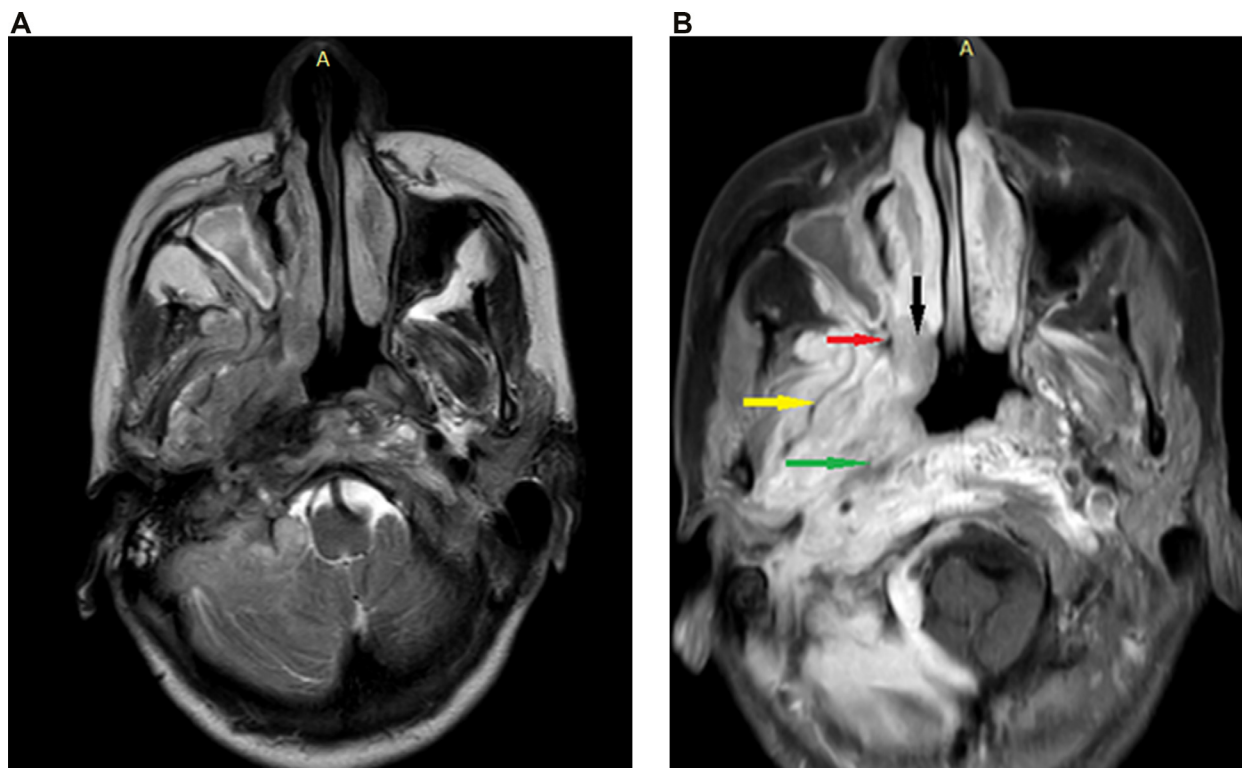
Orbitocerebral MRI, Axial T2 weighted (a) T1-weighted contrast-enhanced FAT suppressed sequences (b) demonstrates an irregular thickening of the right posterolateral wall of the nasopharyngeal in homogenous isosignal T2, heterogeneous enhancement with demonstrates internal cystic components associated with infiltration of the right parapharyngeal space, green arrow) pterioigid muscle (yellow arrow), pterygopalatine fossa (red arrow) Choana (black arrow). (Online version of figure is available online.)
